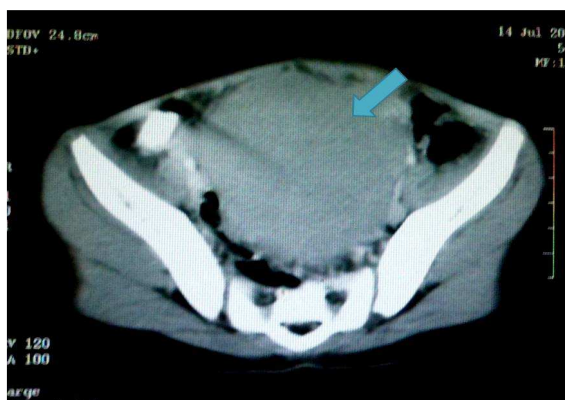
Axial contrast enhanced CT of pelvis through the porto-venous phase reveals a large (approximately 8x7cm), lobulated, homogeneous mass lesion with mild enhancement occupying the pelvis. No evidence of any necrosis/ calcification is evident. Left ovary was not seen separately from the mass.
